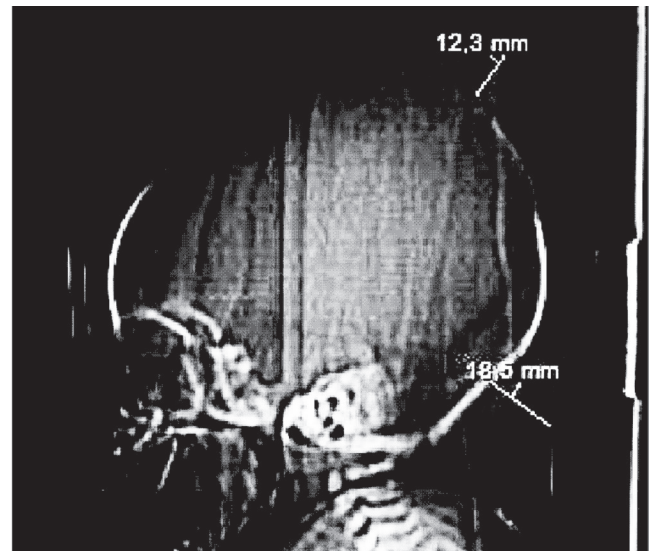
Panoramic CT scan of the patient No. 2.
